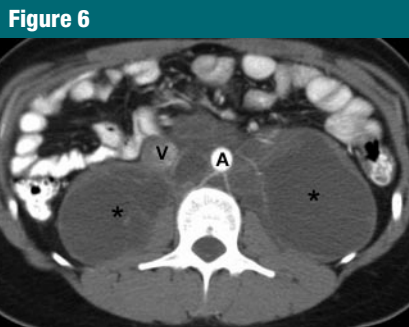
Transverse 5-mm-thick contrast-enhanced CT section through lower abdomen in a 25-year-old woman with LAM and large multiseptated complex retroperitoneal mass consistent with LALM. Note anterior displacement of aorta (A) and IVC (V) by the mass (*).
